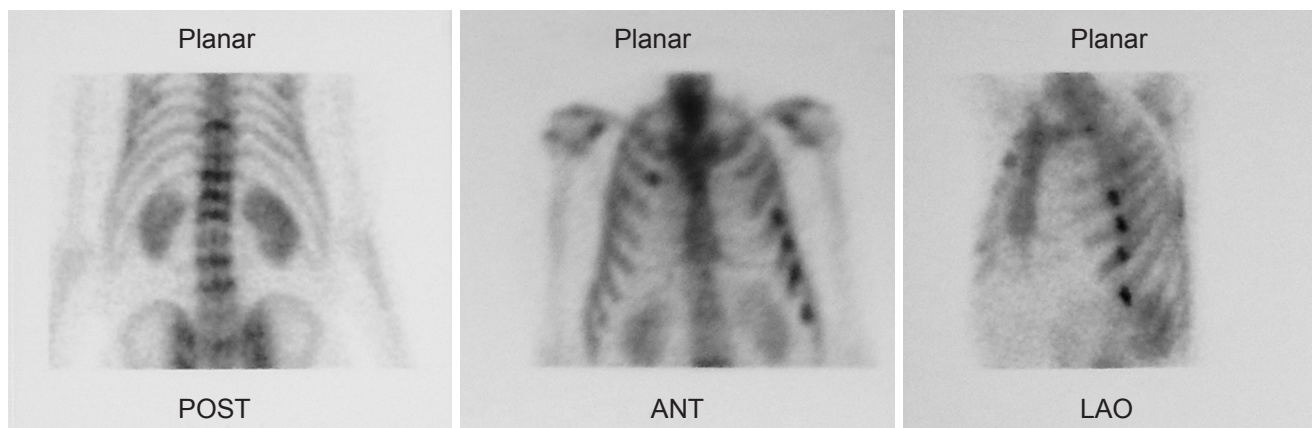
Initial 99m Technetium helix destabilizing protein scintigraphy showing metastatic lesions in the spine and ribs. POST: posterior; ANT: anterior; LAO: left anterior oblique
